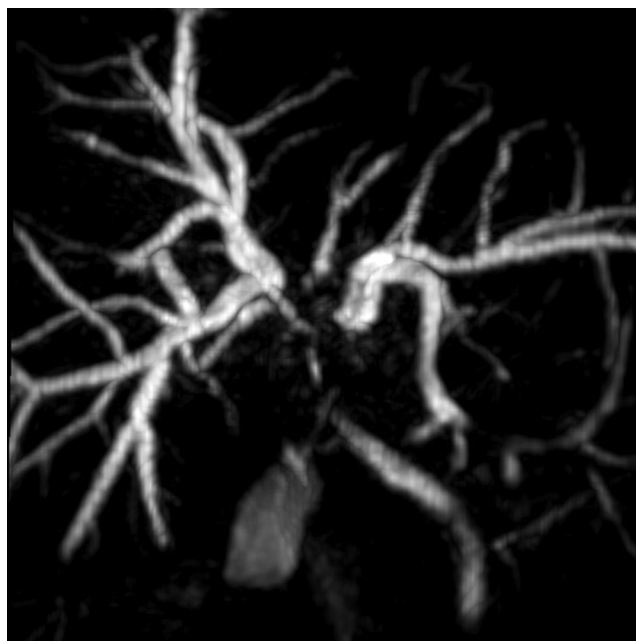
Magnetic resonance image of Klatskin cholangiocarcinoma.
